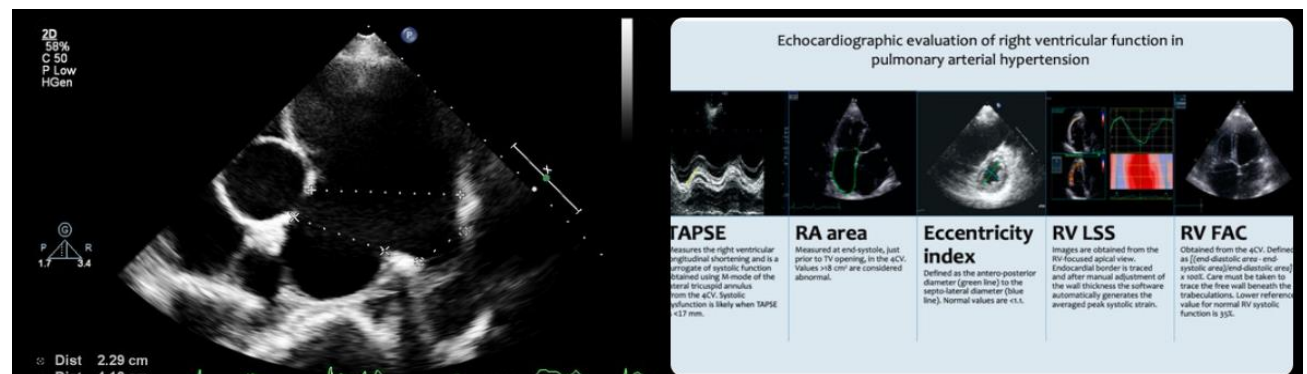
Parasternal short-axis view demonstrating dilation of the main pulmonary artery, typical of chronic pulmonary hypertension
